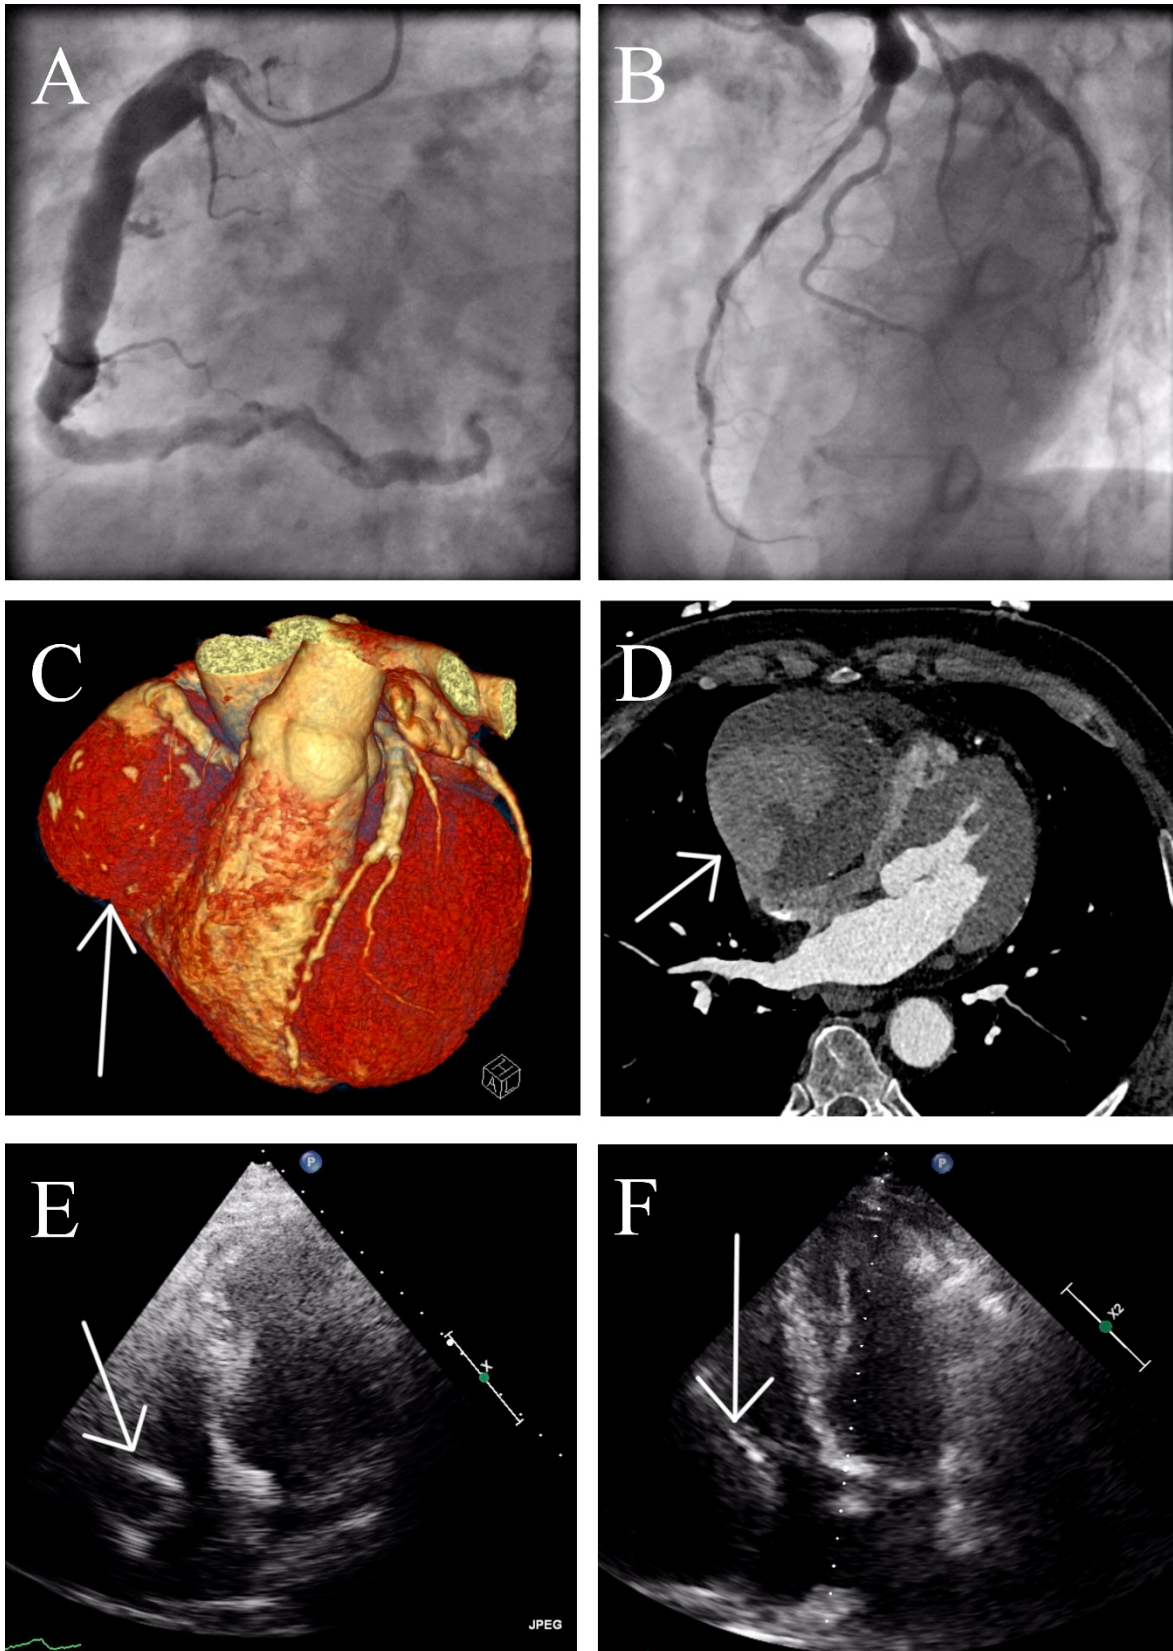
The diagnostic images of the coronary artery ectasia (CAE). A, B. The right CAE and disseminated ectasias in other vessels in an initial coronary angiography. C. The digital reconstruction of giant right CAE based on computed tomography angiography performed
